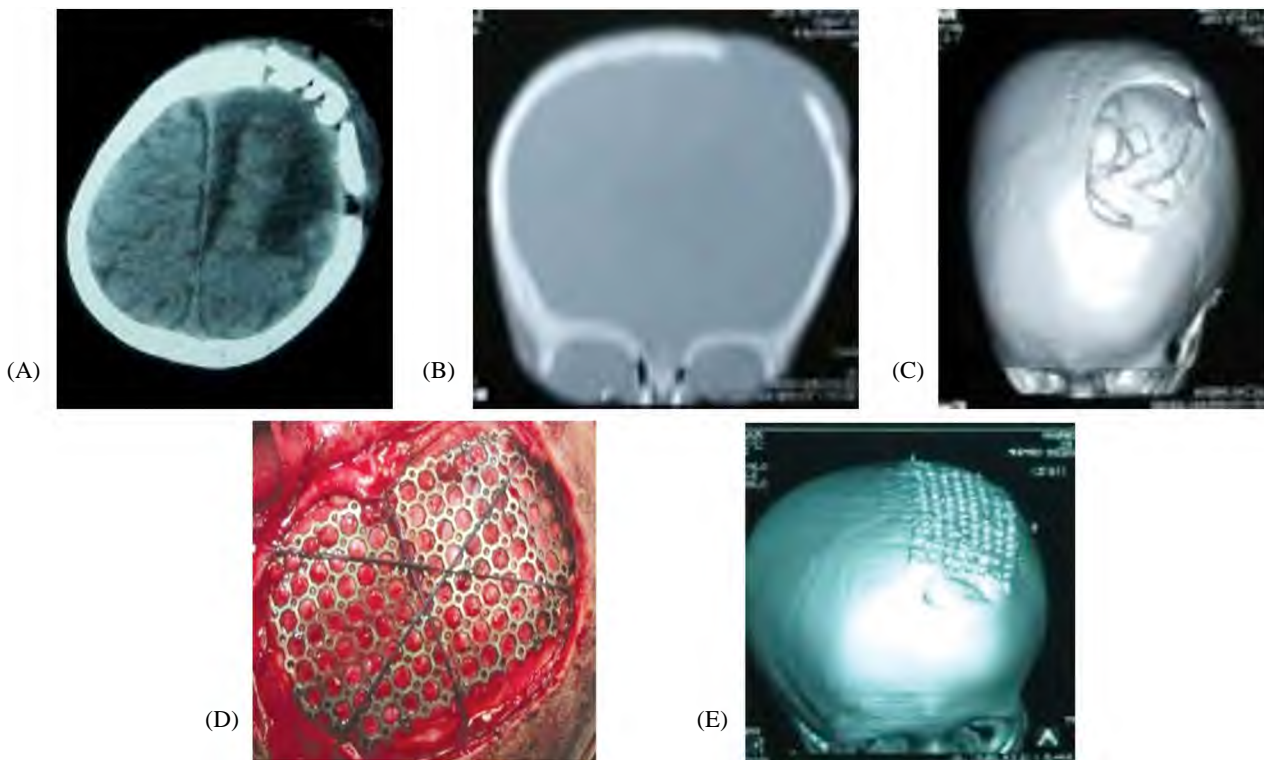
(A) CT brain axial cut showing reconstruction of left parietal skull defect with rib graft. (B) Bone window of CT brain “coronal view” showing recurrence of the skull defect due to resorption of rib graft. (C) CT 3D reconstruction demonstrating the defect and remaining part of the graft. (D) Intraoperative image showing the titanium mesh in place , note sutures stretching the periosteum over the edge of the mesh that avoid erosion of the scalp over the mesh edges. (E) Follow-up CT 3D reconstruction revealing adequate skull reconstruction.
